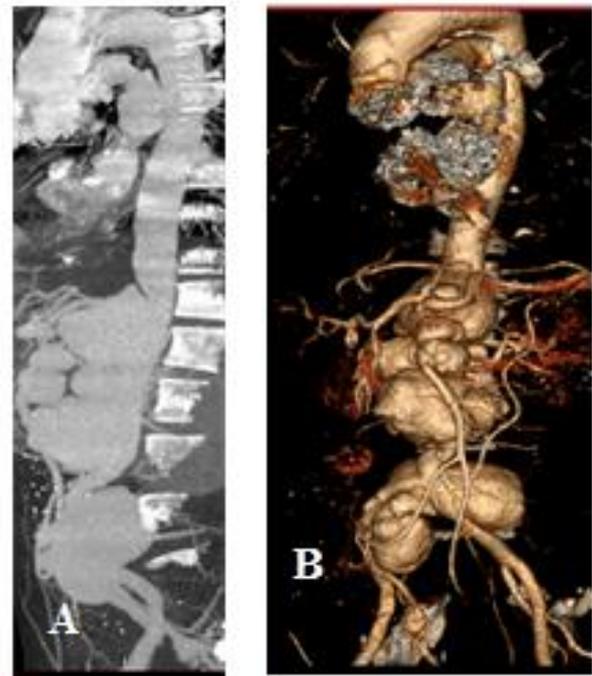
Multisegmental aortic saccularform aneurysms. CT angiography of the thoracoabdominal aorta. 3D reconstructions in right side view (A) and in front view (B) showing multi-stage aortic aneurysms up to primary iliac arteries
